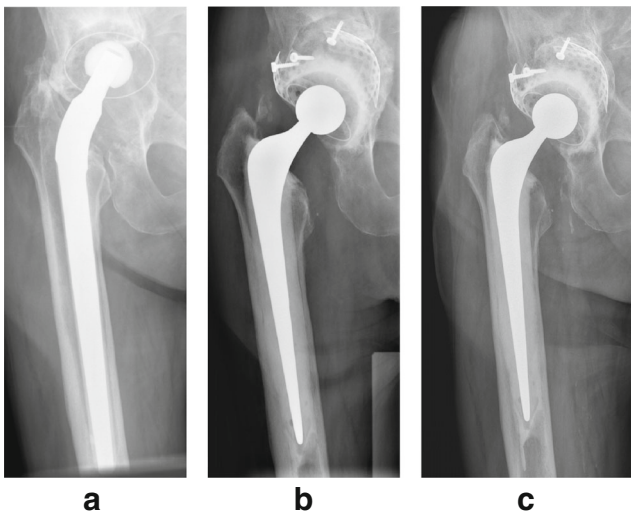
Radiographs of a revision in which meshes and impaction bone grafting were used. The patient was 87 years old at time of surgery. a Preoperative anteroposterior radiograph of an uncemented total hip arthroplasty with aseptic loosening and extensive bone loss of the acetabulum and femur. b Anteroposterior radiograph two months after the revision total hip arthroplasty. First, the extensive acetabular defects were reconstructed with a medial and superolateral rim mesh to create contained defects. After that, acetabular impaction bone grafting was performed with three morselized allograft femoral heads. Because the patient already lost three liters of blood at the time of the surgery and was 88 years old, it was decided to cement the new femoral component without performing impaction bone grafting to replenish the bone stock loss in the femoral cavity. c Anteroposterior radiograph after eight years follow-up. The patient is 95 years old. Both the acetabular and femoral component are totally stable, and on the acetabular side complete incorporation of the graft took place
